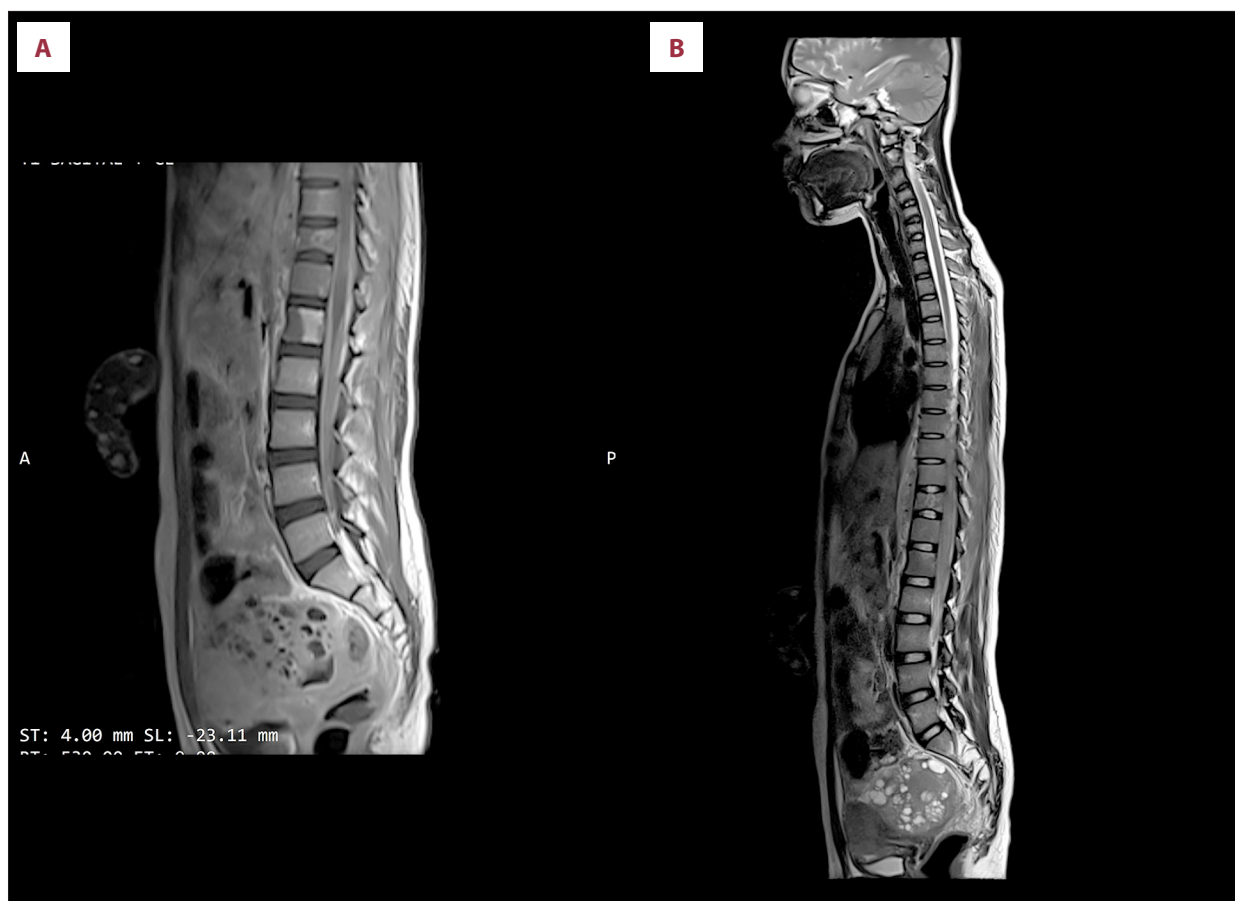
(A) Contrast-enhanced lumbar magnetic resonance image (sagittal view) demonstrating altered signal intensity of the L1 vertebra with a paravertebral mass extending from L1 to L3. (B) Contrast-enhanced thoracic magnetic resonance image demonstrating left-sided pleural effusion, compressive atelectasis involving segments 6 and 10 of the left lung, an anterior mediastinal lesion, a paravertebral mass, and bilateral adnexal masses.
